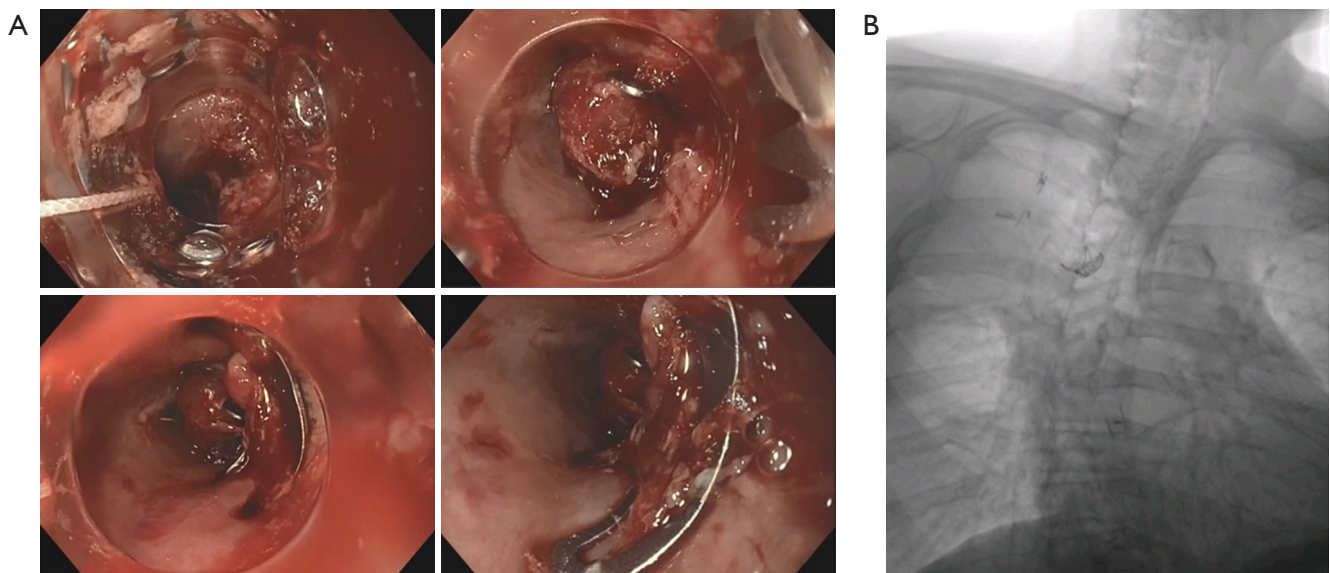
Over-the-scope clips in an acute intrathoracic esophageal perforation. Patient with iatrogenic esophageal perforation and a prior chest surgery: (A) endoscopic images of over-the-scope clip placement; the same patient after endoluminal procedure; (B) antero-posterior images chest X-ray.
